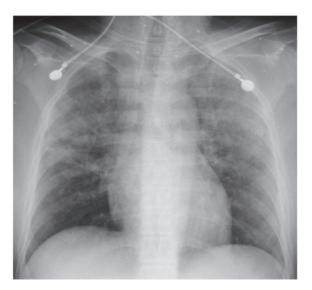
Chest radiograph performed on admission detected bilateral ground-glass opacities in each lung.
